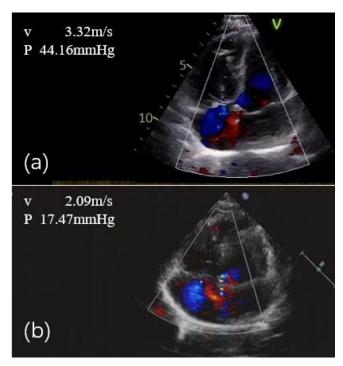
Patient's Echocardiogram before and follow-up after treatment with Luspatercept. (a) Presented the patient's Echocardiogram prior to Luspatercept treatment, showing a tricuspid regurgitation jet velocity of 3.32 m/s, a tricuspid valve pressure gradient of 44.16 mmHg, and an estimated pulmonary artery systolic pressure of 49 mmHg; (b) Presented the patient's Echocardiogram 21 months after Luspatercept treatment, showing a tricuspid regurgitation jet velocity of 2.09 m/s, a tricuspid valve pressure gradient of 17.47 mmHg, and an estimated pulmonary artery systolic pressure of 17 mmHg.
